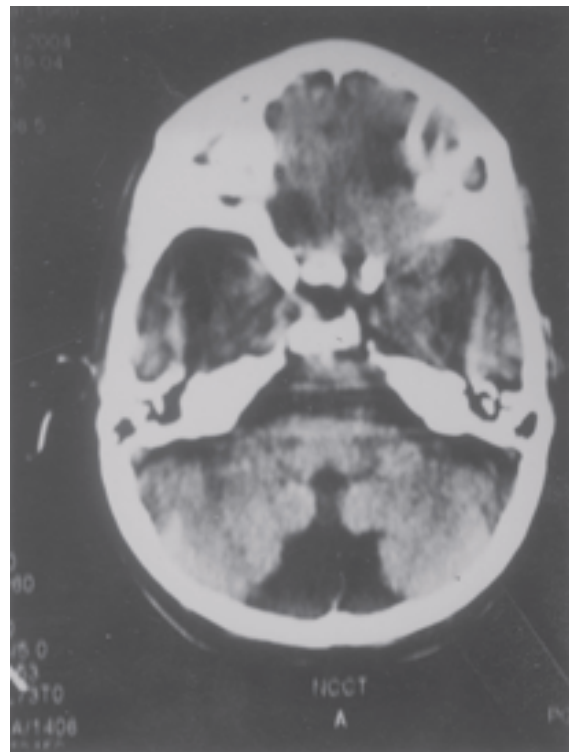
Spiral CT scan showing partial agenesis of cerebellar vermis and dilatation of IVth ventricle, communicating with cisterna magna.
